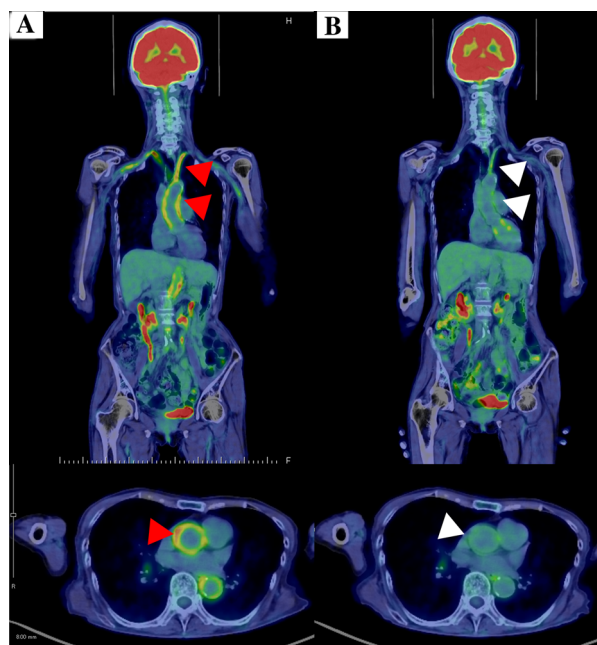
Initial ^{18}F -fluorodeoxyglucose (FDG) positron emission tomography (PET)/CT demonstrates increased FDG uptake in the thoracoabdominal aorta, and along the carotid and subclavian arteries (red arrows), with a single horizontal slice at the pulmonary trunk level (A). In contrast, the enhanced FDG uptake (white arrowheads) almost disappeared after the 3-week oral corticosteroid therapy (B).
